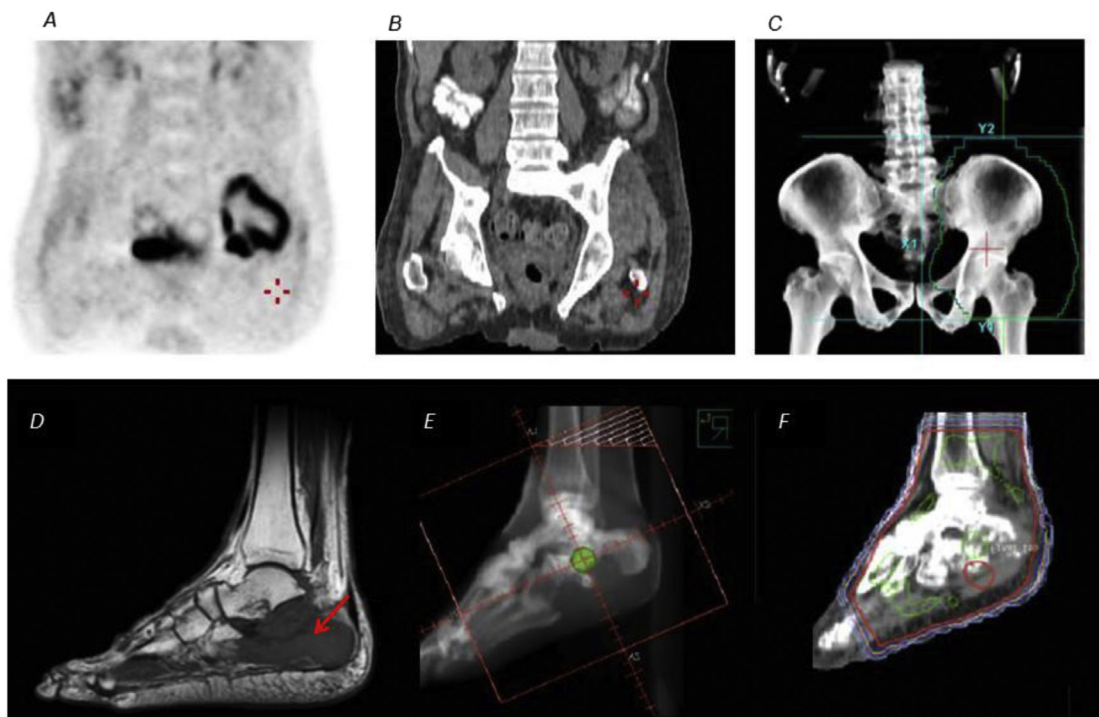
(A) Chloroma in the left pelvis on positron emission tomography and (B) coronal computed tomography scans. (C) Radiation treatment field (green line). (D) Chloroma in the calcaneus as seen on a T1 magnetic resonance imaging scan (arrow). (E) Radiation treatment fields. (F) Dose distribution. Red line represents the 20-Gy isodose line. (A color version of this figure is available at www.redjournal.org.)
